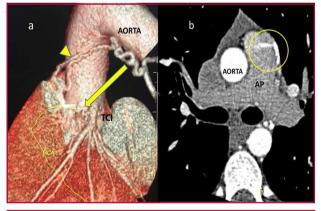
Three-dimensional cardiac CT scan reconstruction (a). The arrow targets the origin of a coronary fistula on the distal left main coronary artery (LMCA), and its anastomosis with a bronchial branch (arrowhead). CT scan image (b) showing a flow jet on the trunk of the pulmonary artery (PA) corresponding to the fistula outlet.
